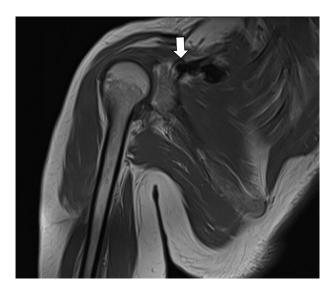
MRI in T1 coronal view demonstrating a mass lesion compressing the suprascapular nerve (white arrow), extending from the supraspinatus fossa to the spinoglenoid notch.
